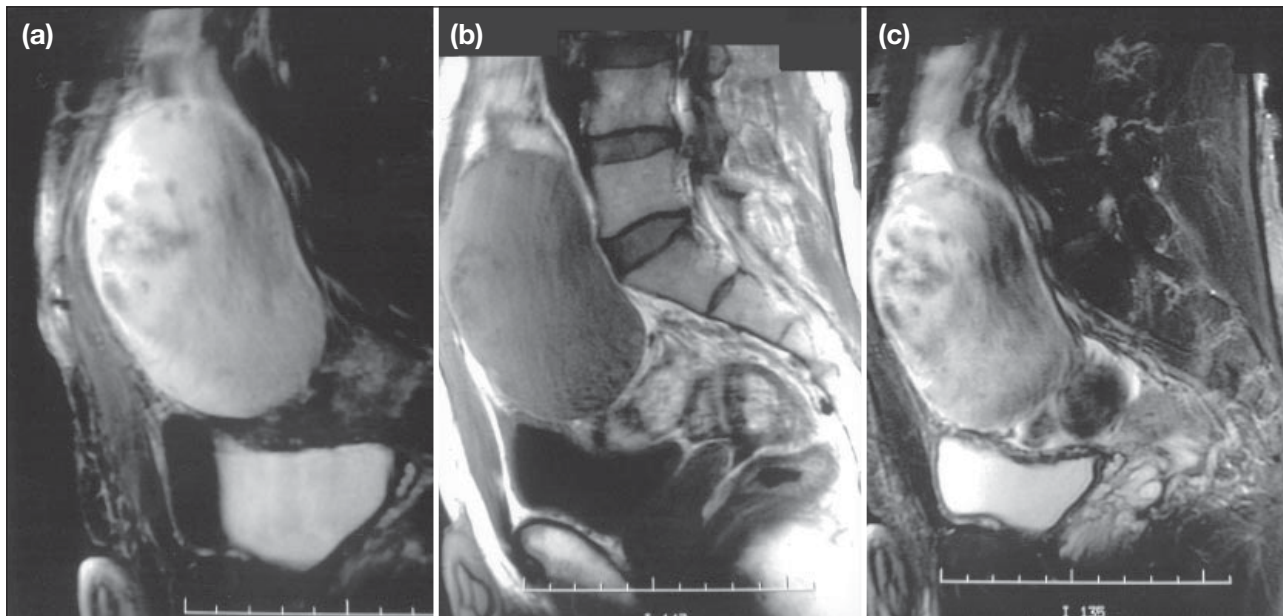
Sagittal magnetic resonance imaging. (a) Sagittal fat saturation T1 image with contrast injection showing the heterogeneously enhancing mass lesion. The contrast enhancement was more readily appreciated with magnetic resonance images compared with computed tomography scan. (b) Sagittal T1 and (c) T2 images of magnetic resonance imaging. The tumour was isointense to hypointense to muscle on T1 image and of mixed high signal intensity on T2 images.
